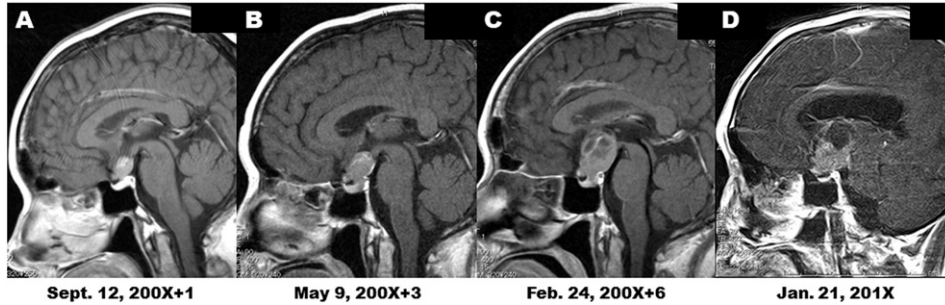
Serial follow-up MRI demonstrates the gradual enlargement of the suprasellar tumor. Preoperative image evaluation reveals slowly progressive atrophy of the pituitary gland on serial MR images (C, D). Serial image evaluation also demonstrates that the tumor grew and extended not only into the third ventricle (C, D) but also into the sella turcica along the pituitary stalk (B, C).
